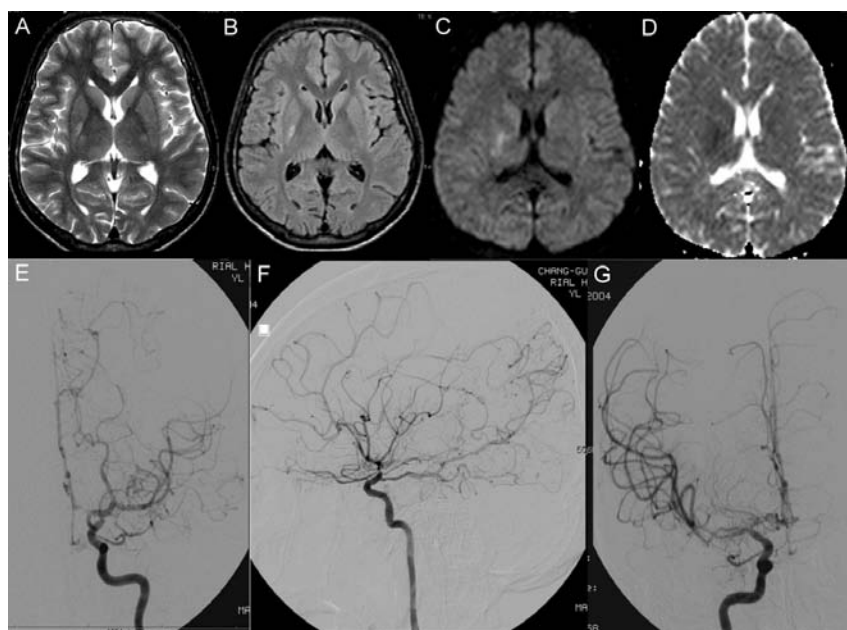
High-signal lesion was noted in right internal capsule posterior limb at T2 weighted image (A), FLAIR (B) and Diffusion weighted image (C). This lesion appeared dark in ADC map (D) denoting recent ischemic stroke. The PA (E) and lateral views (F) of the angiography on the left internal carotid artery (ICA) showed marked narrowing of left distal ICA, middle cerebral artery (MCA) M1 and anterior cerebral artery (ACA) A1 segments with leptomeningeal collaterals from the left posterior cerebral artery. The stenosis in the right MCA M1/2 segments was also noted in the PA view of the angiogram on the right ICA (G).
